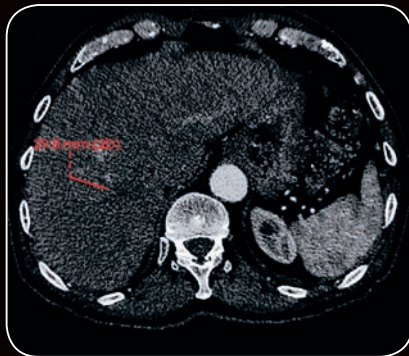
CT at early portal venous phase
